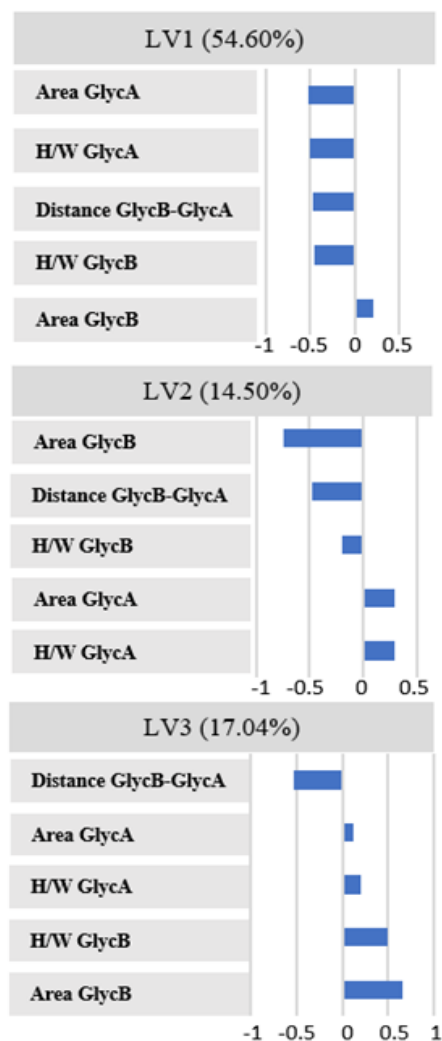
PLS-DA loading plot showing the NMR glycoprotein-derived parameters contributing to the separation of the PLS-DA scores in RA patients and CT individuals.
